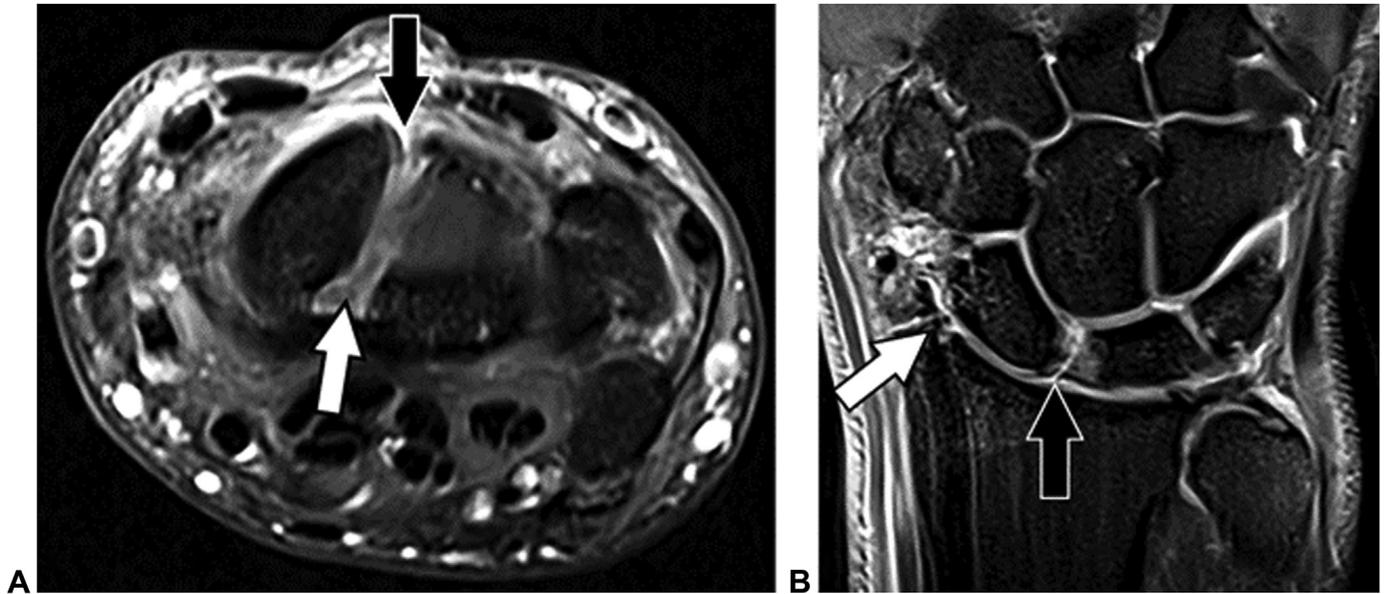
Stage 5 SLIL injury in a 30-year-old professional American football player. A Axial PDW fat-suppressed MR image shows a torn SLIL dorsal band (black arrow) and torn SLIL volar band (white arrow). B Coronal PDW fat-suppressed MR image shows cartilage loss, most prominent at the articulation of the radial styloid and scaphoid, with osteophyte formation (white arrow) and a torn SLIL interosseous band (black arrow). (Adapted with permission from Palisch et al¹⁰¹).
